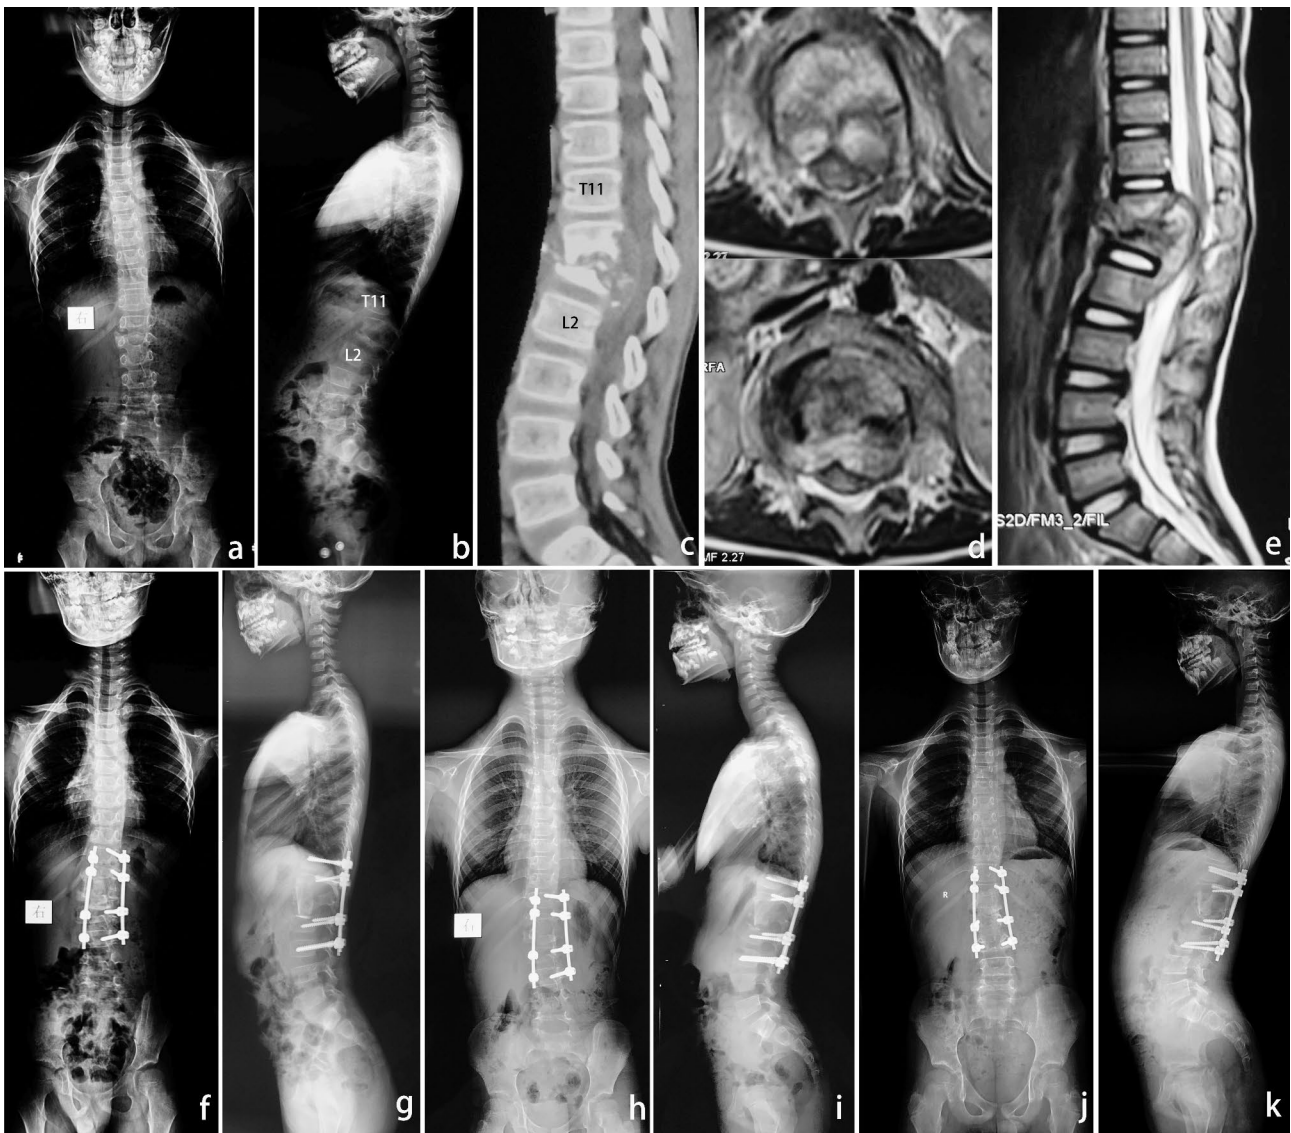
(a-e) Preoperative images of a 5-year-old boy showing T12/L1 involvement, as well as the protrusion of dead bone fragments into the spinal canal; (f, g) A posterior-only approach was performed; (h, i) Six-month postoperative radiographs showing a good position of the internal fixation and strut bone; and (j, k) X-rays showing no obvious loss of correction 40 months postoperatively, with a solid fusion
